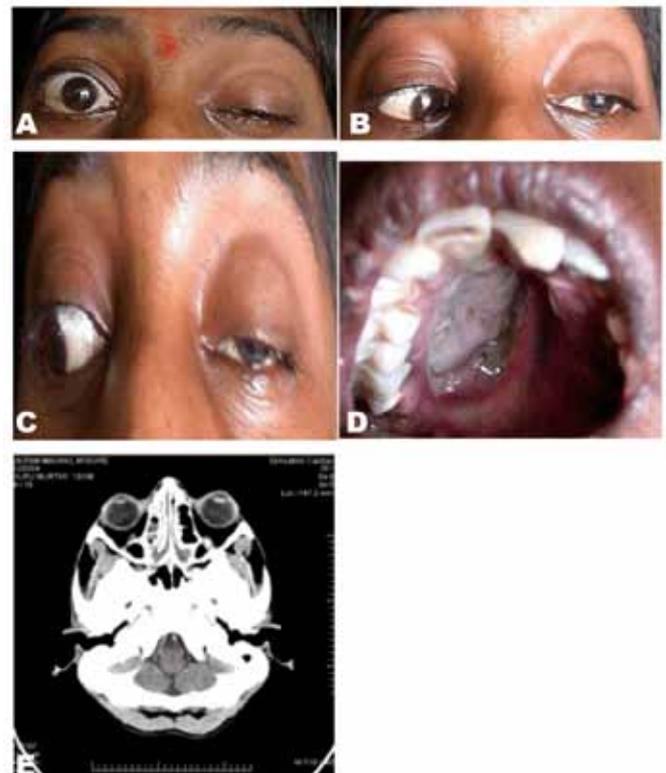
Known type 1 diabetic presenting with orbital mucormycosis with (A-C) multiple cranial nerve palsy, with (D) palatal perforation, and (E) computed tomography scan showing infiltration of left superior orbital fissure.
